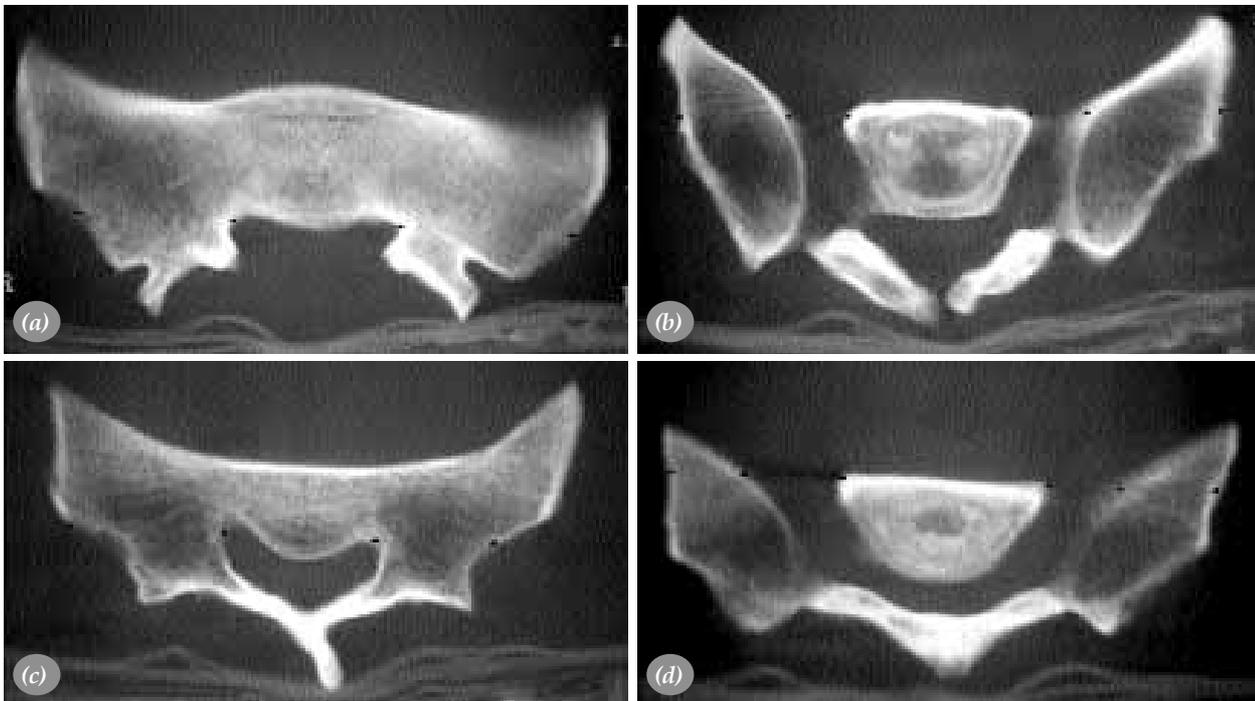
In the cross sections of CT; (a) the view of lateral sacral masses on both sides and neural canal in the center of the cross section at S₁ pedicle-body level, (b) the view of "LSM-IVF- S₁ corpus-IVF-LSM" in the cross section at S₁ intervertebral foramina/foramen level, (c) the view of S₂ pedicle and LSM on both sides and neural canal in the center of the cross section at S₂ pedicle-body level, (d) the view of "LSM-IVF- S₂ corpus-IVF-LSM" in the cross section at S₂ intervertebral foramina/foramen (IVF) level.
